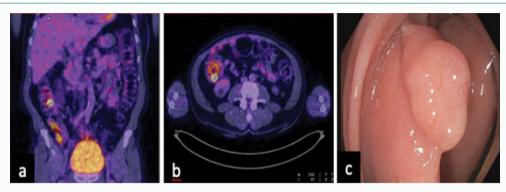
PET-CT performed in a 67-year-old patient because of melanoma. Incidental FDG uptake was recorded in the ascending colon (SUVmax 26.5). a, b) Intraluminal nodular image showing focal increase of metabolism; c) Sessile polyp in ascending colon of 15 mm, corresponding to the PET-CT finding.
